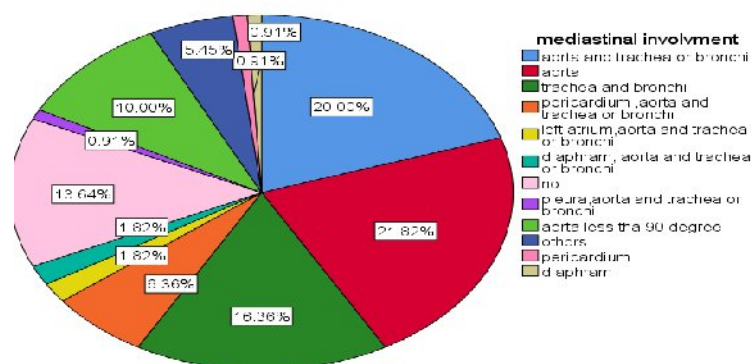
Mediastinal involvement by esophageal ca in the study participants that CT imaging pattern ,associated risk factors and prevalence of pneumonia of esophageal cancer patients scanned for staging in the Department of Radiology, TASH, Addis Ababa, Ethiopia 2019
